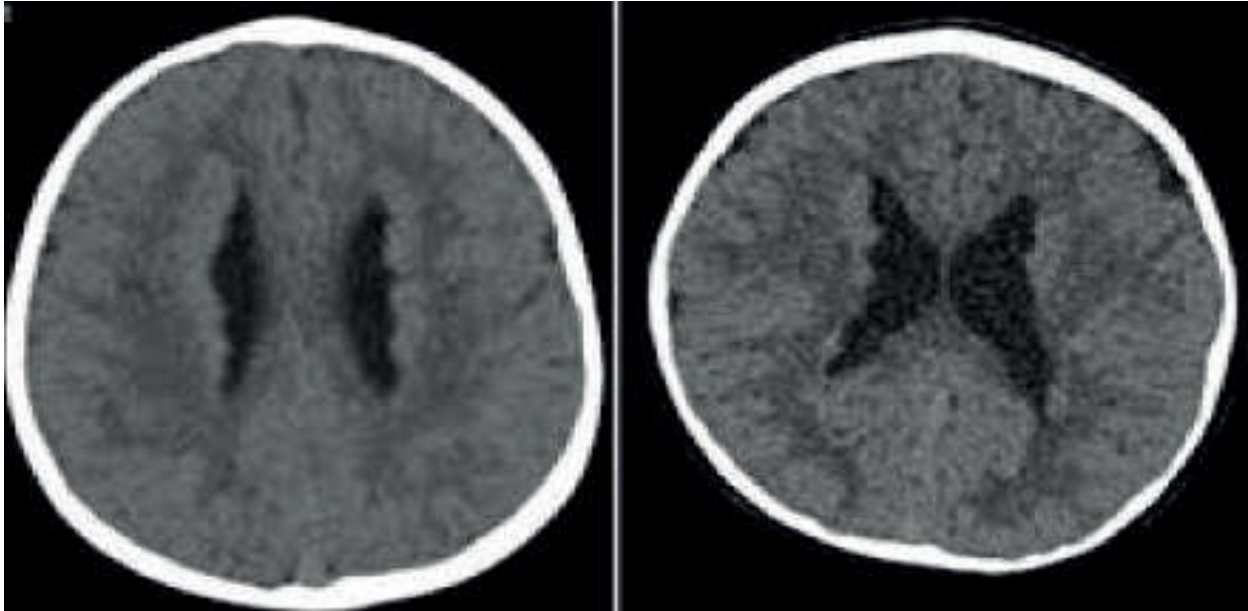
Brain CT scan revealing the nodular heterotopic grey matter along the lateral ventricles giving them a ragged appearance.
